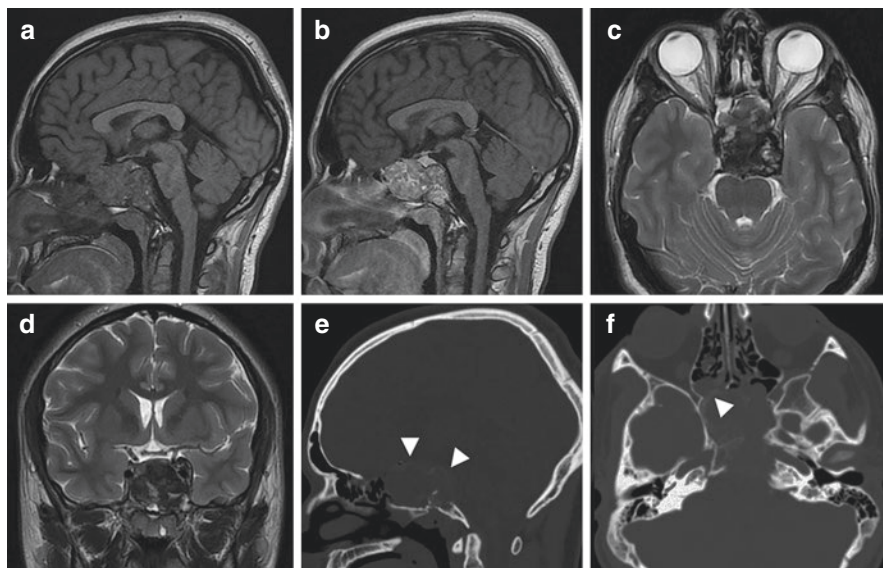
Clival fibrous dysplasia. MR images (a–d) demonstrating a large clival mass. Note the bony expansion in the CT images (e, f; arrowheads)
